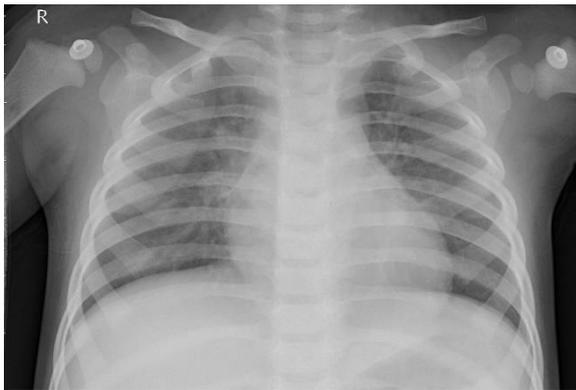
pneumonia Chest X-Ray
